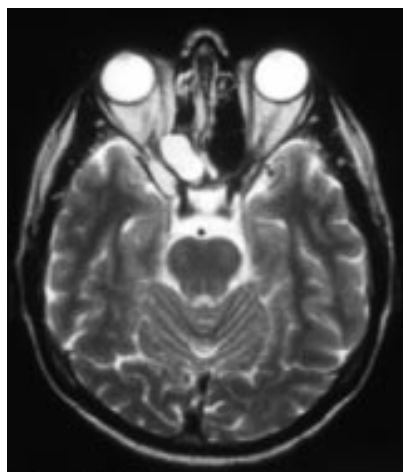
Axial T2 weighted magnetic resonance image of the orbit showing a kidney bean-shaped mass of 1 × 2 cm and high signal intensity in the right orbital apex.
